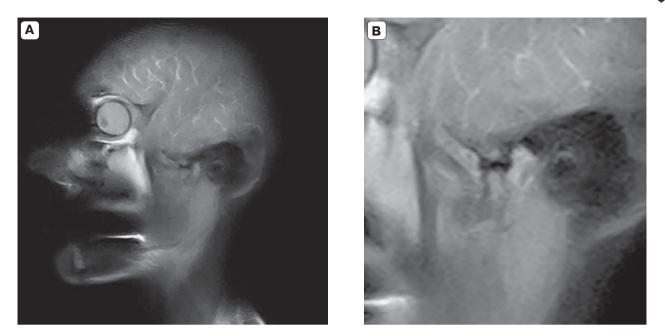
MRI of the TMJ considering metal structures in the ROI, sagittal plane. A - T2 FSE, open mouth position; B - T1 FSE, closed-mouth position.
